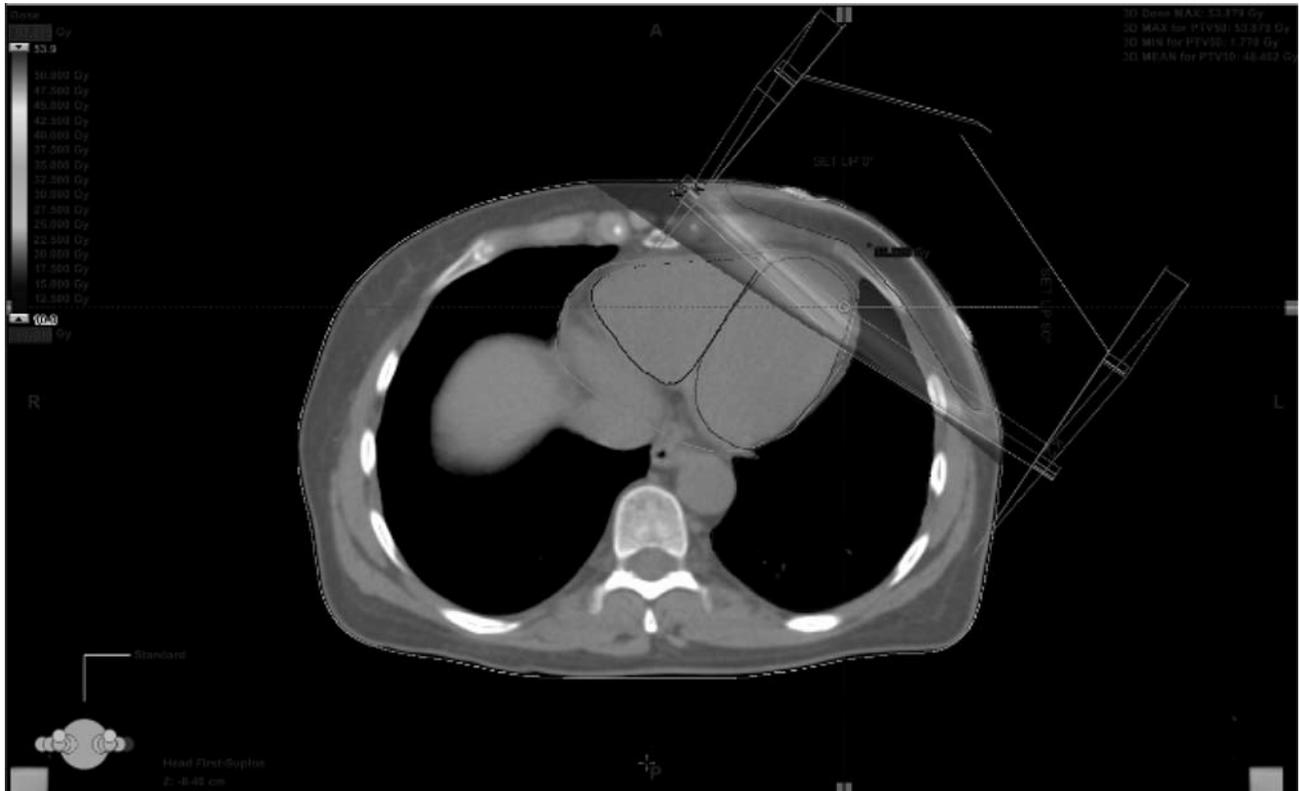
Three-dimensional (3D) computed tomography (CT) treatment planning. Target volume is planned to cover remaining breast tissue. The dark area shows sites achieving more than 10 Grays with highest dose in the apex. Manually depicted heart contouring is also shown for the whole heart, left ventricle, right ventricle, right ventricle's free wall.
